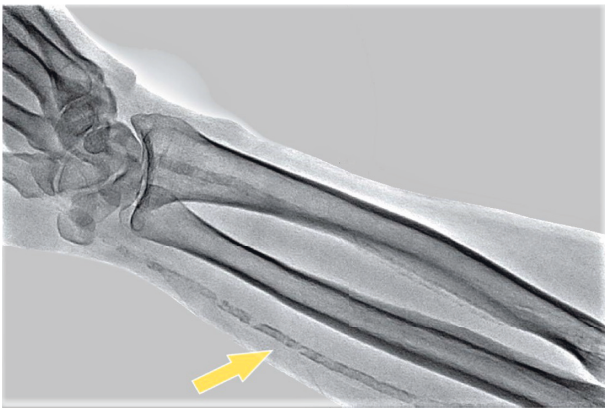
Forearm radiography: diffuse mediocalcinosis along the entire length of the radial artery (arrow).
